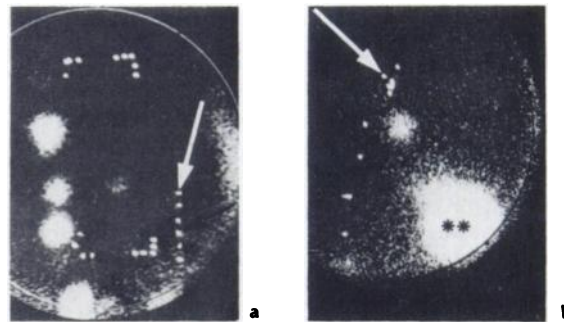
Internal mammary lymph nodes visualized by orthogonal scintigram in cancer of left breast. a. Anterior view, made 6 hr after left-side and 3 hr after right-side injection of the microcolloid. Right chain is well visualized, but only one node is visible in the left chain. Rectangular mammary field is indicated and seems to cover left mammary chain. Arrow shows dots 1 cm apart. b. Another case of breast cancer. Left lateral view of thorax. Bright points show contour of anterior chest wall. Arrow indicates sternal notch (\*\*: left intercostal deposit of microcolloid for axillary scintigraphy.)
